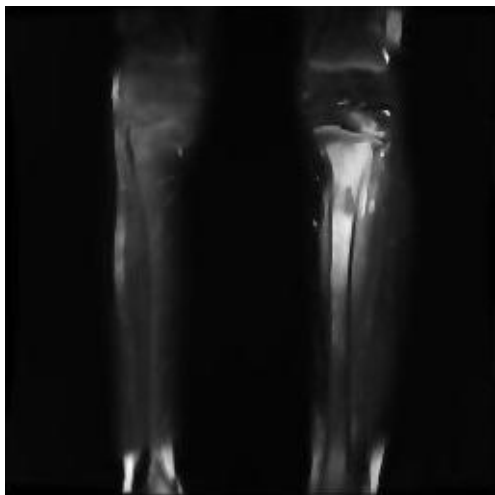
T2-weighted MR image of Ewing's sarcoma after anisotropic diffusion filtering.
